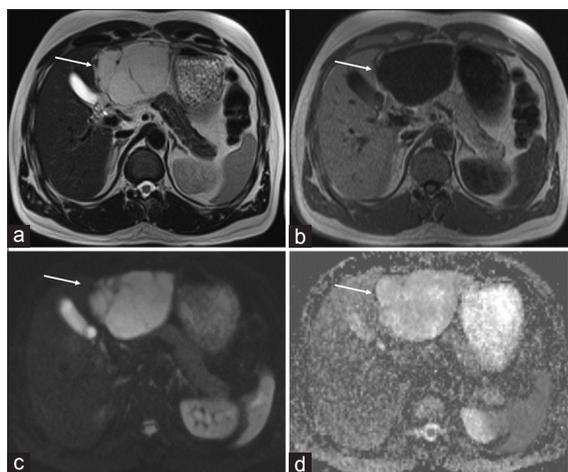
Magnetic resonance images of the same patient as Figure 8. Axial T2-weighted images showing large homogeneously hyperintense lesion with few septae in the left lobe of the liver (white arrow, a) and appearing homogeneously hypointense on T1 images (white arrow, b). Axial diffusion-weighted magnetic resonance image showing homogeneously hyperintense signal in the lesion (white arrow, c) and apparent diffusion coefficient map showing hyperintense signal corresponding to diffusion-weighted imaging suggesting no e/o diffusion restriction within the lesion (white arrow, d) with mean apparent diffusion coefficient value $1.68 \times 10^{-3} \text{ mm}^2/\text{s}$
